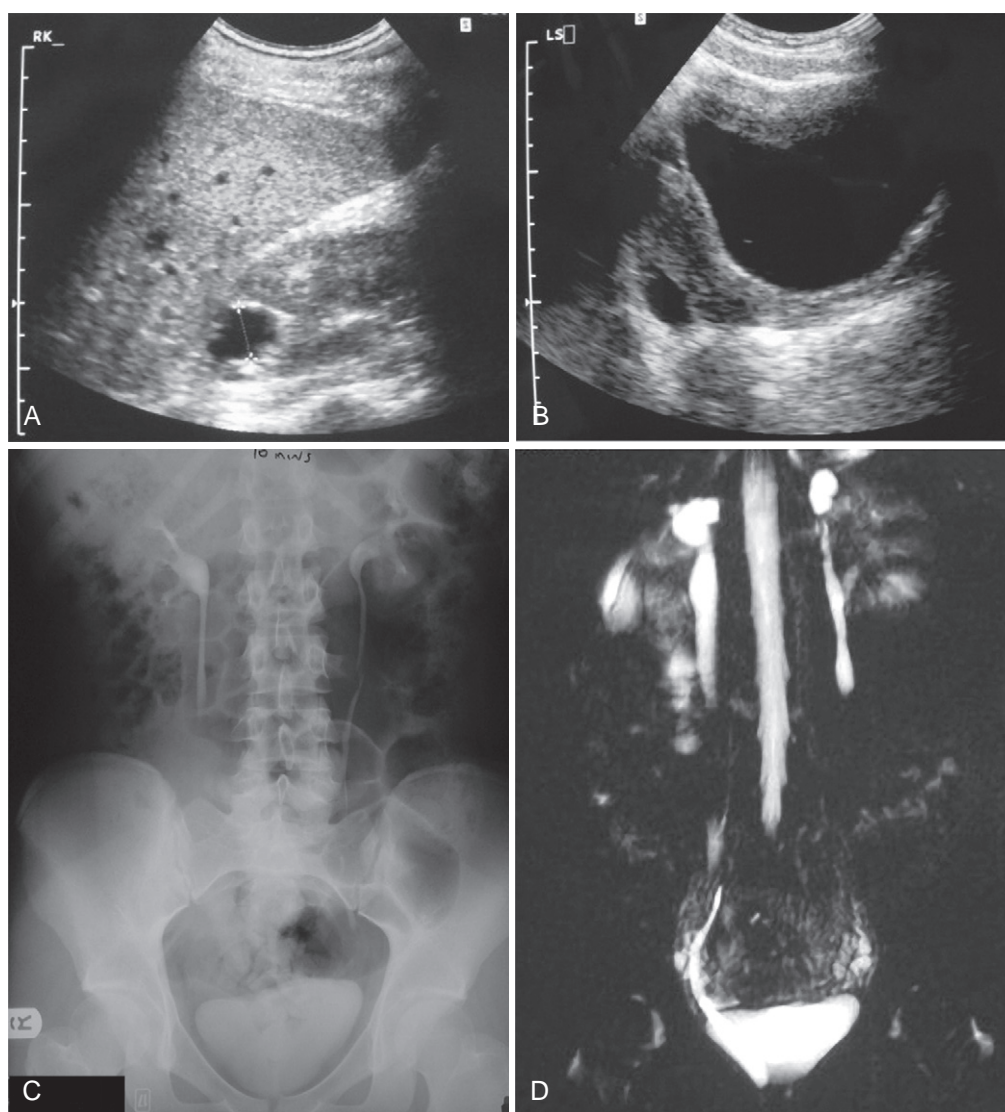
A case of ectopic ureter causing incontinence in a young girl. The ultrasound shows a dysplastic upper pole (A) with a dilated ureter behind the bladder (B). Excretory urogram is unremarkable (C), but magnetic resonance imaging (MRI) shows the ureter opening well below the bladder (D). This girl had bilateral ectopic upper pole ureters as diagnosed on the MRI.
